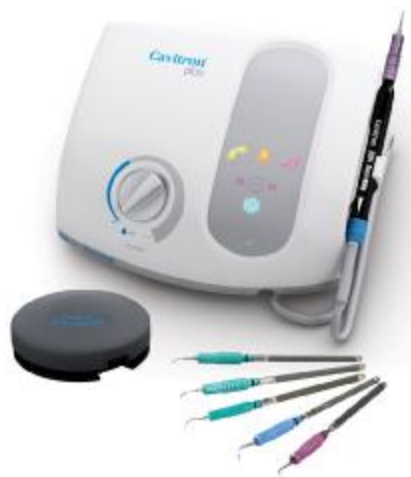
Cavitron (Dentsply) and Enac (OSADA) ultrasonic units
